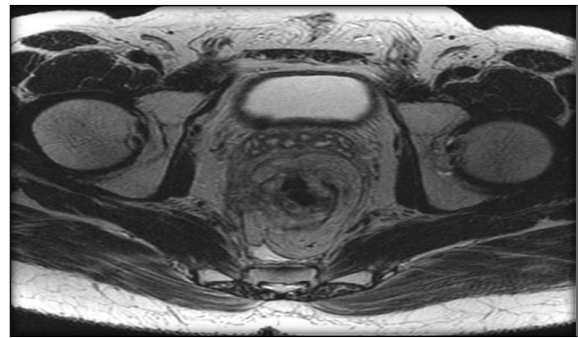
AXIAL T2W MRI shows polypoidal lesion in the mid/lower rectum, categorized as T2 tumor
